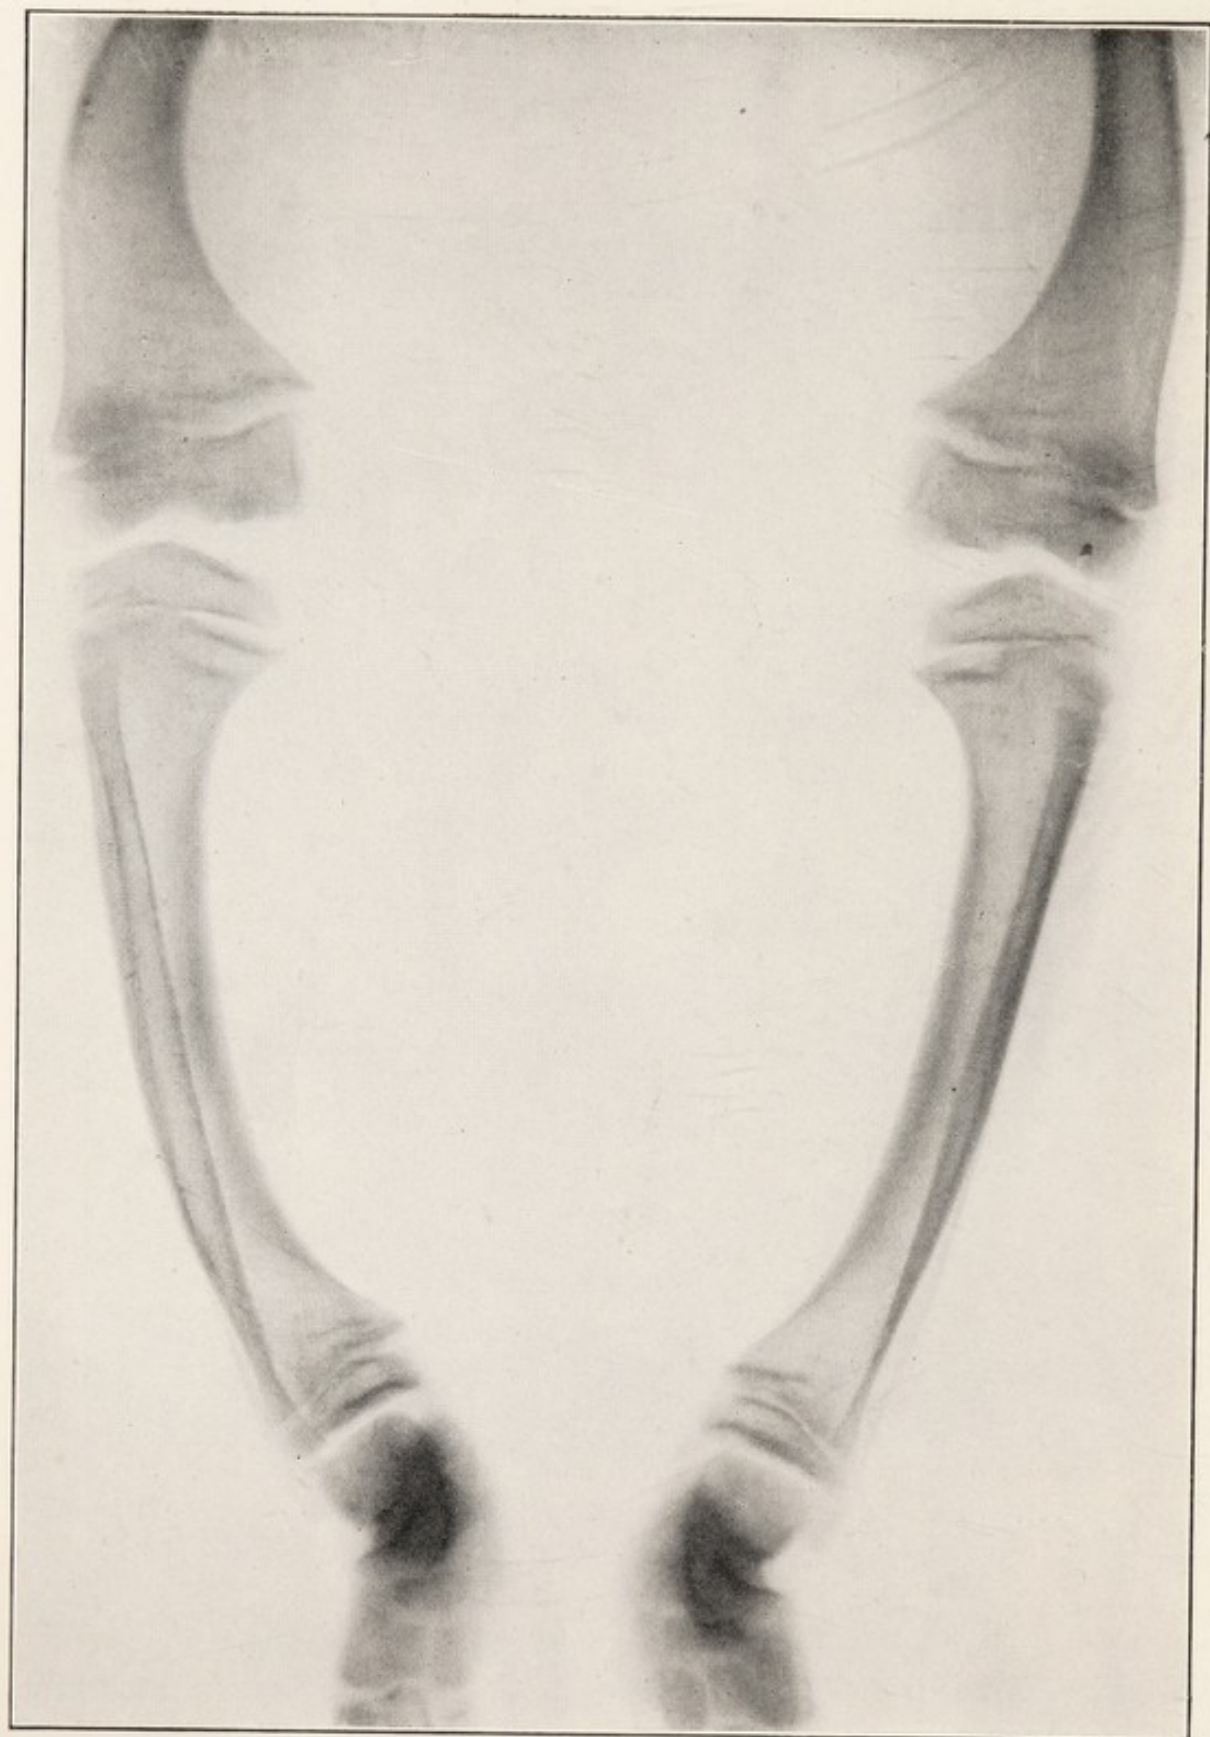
X-RAY OF BOW-LEG FOLLOWING RICKETS.
